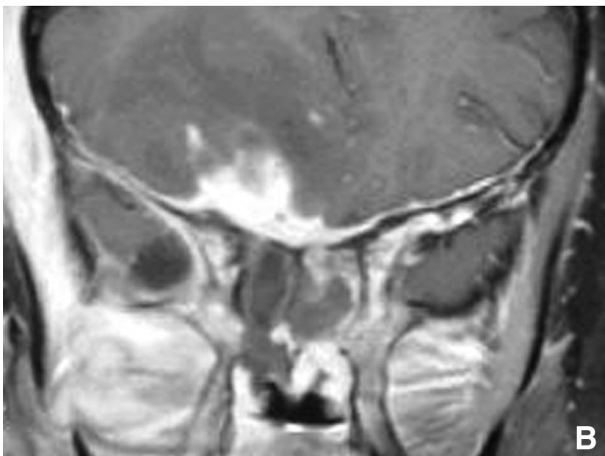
A, Coronal CT scan from initial treatment (June 29). Orbital fat is still unremarkable but the extraocular muscles are markedly thickened. B, MRI obtained at our hospital: Fat suppressed gadolinium-enhanced coronal T₁-weighted MRI. There are multiple areas of increased signal intensity in both orbital apices. There is also meningeal infiltration of the skull base (anterior cranial fossa), a large area of edema in the right cerebral parenchyma, and temporal and infratemporal fossae infiltration.
